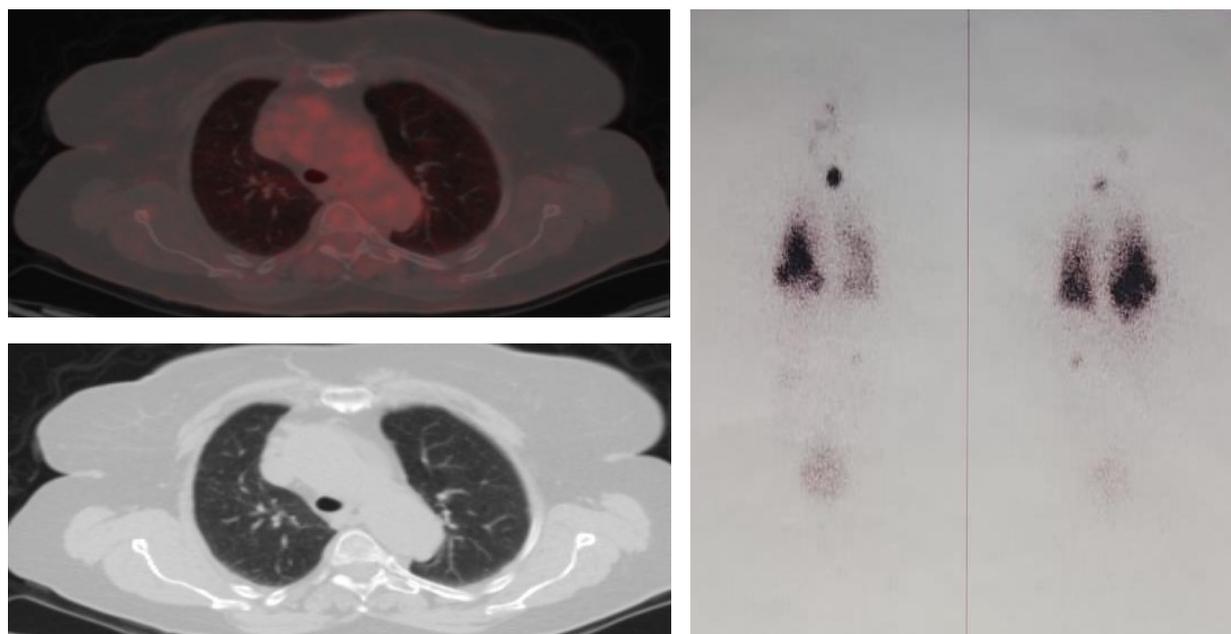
Anterior and posterior I-131 WBS and spot chest views post (100mci) with imaging after 7 days showing iodine avid residual functioning thyroid tissue and bilateral diffuse lung metastases while the PET/CT fused image and the CT image showed no metabolically active FDG avid lung lesions due to being diffuse micro metastases which predicts good prognosis and well differentiation.
